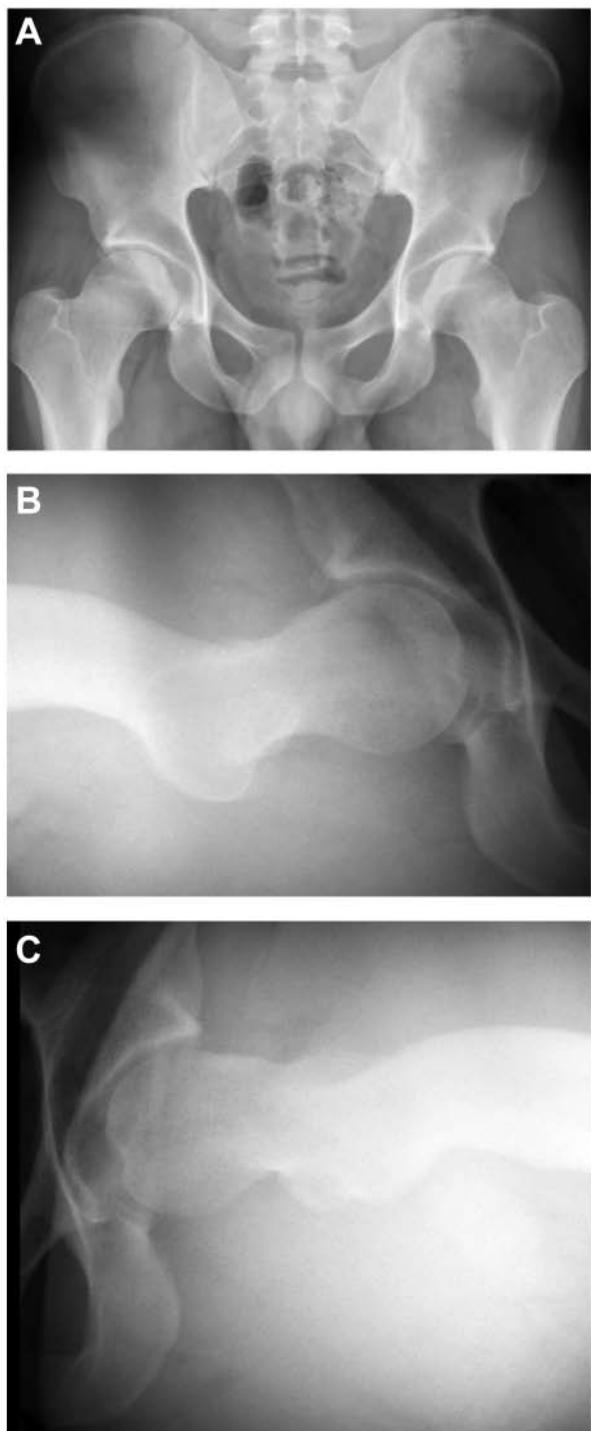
Preoperative radiographs. (A) Anteroposterior view of the pelvis and Dunn lateral view of the (B) right and (C) left hip. This is a 19-year-old male patient who had bilateral femoroacetabular impingement. There is marked acetabular retroversion and cam-type impingement, with a high degree of symmetry from side to side.
